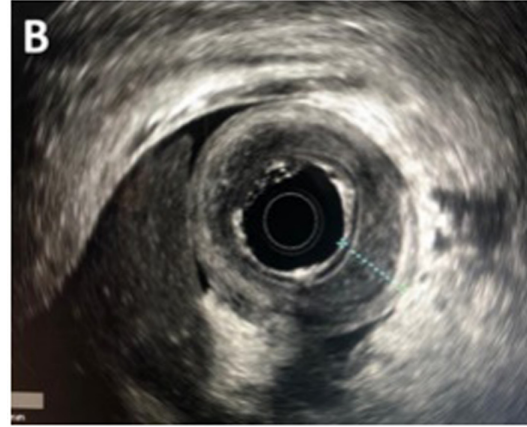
Endoscopic ultrasonography image: Prominence in the submucosa of the antrum (9 mm).
